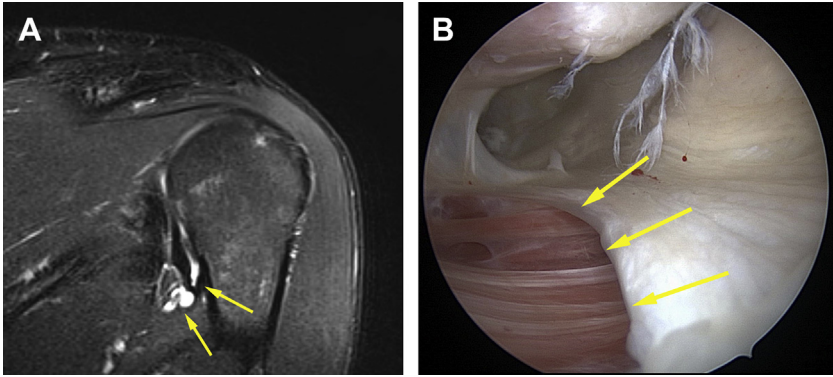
Magnetic resonance image showing avulsion of the glenohumeral ligaments on from their proximal humeral insertion (HAGL lesion) (arrows, A). Arthroscopic appearance of an HAGL lesion (arrows, B).
